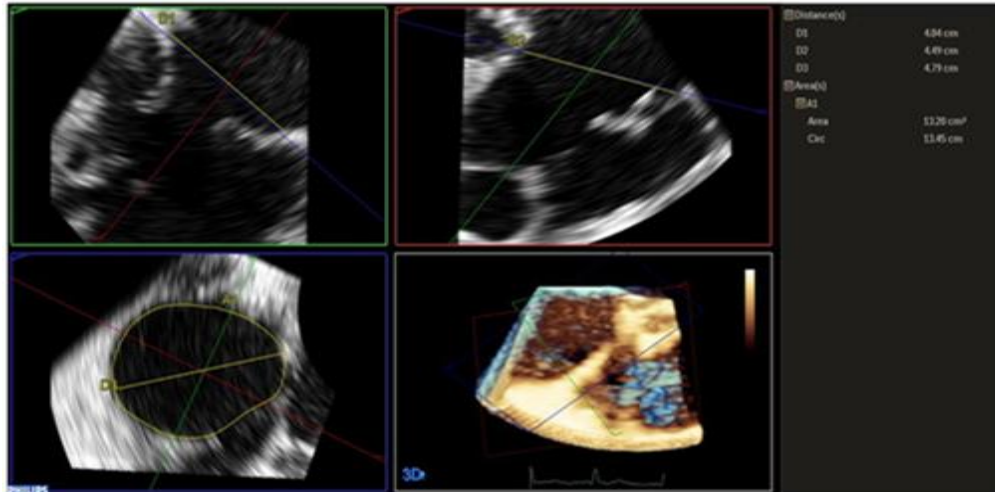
Tricuspid annular measurement, Tricuspid annular measurements using multiplanar reconstruction (MPR) from 3D transesophageal echocardiography. The septal-lateral and antero-posterior diameters, as well as annular area and perimeter, were assessed at end-diastole using orthogonal planes and planimetric tracing.
